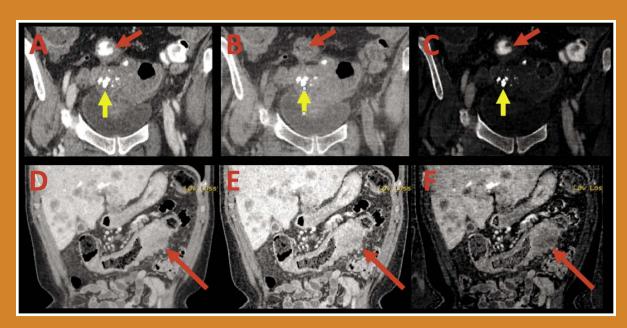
Coronal CT images showing the benefits of material discrimination at Dual-Energy CT. A) Regular CT: rectal contrast (red arrow) is difficult to differentiate from unknown extralumenal densities (yellow arrow). B) DECT water map: Rectal contrast has been digitally suppressed, while the unknown density remains visible, indicating that it is not the rectal contrast: it is a calcified fibroid. C) DECT iodine map. D) Regular CT: Tumor necrosis (red arrow) is not easily identified. E) DECT water map F) DECT iodine map: the tumor necrosis is more easily seen, as are hypovascular liver metastases.
